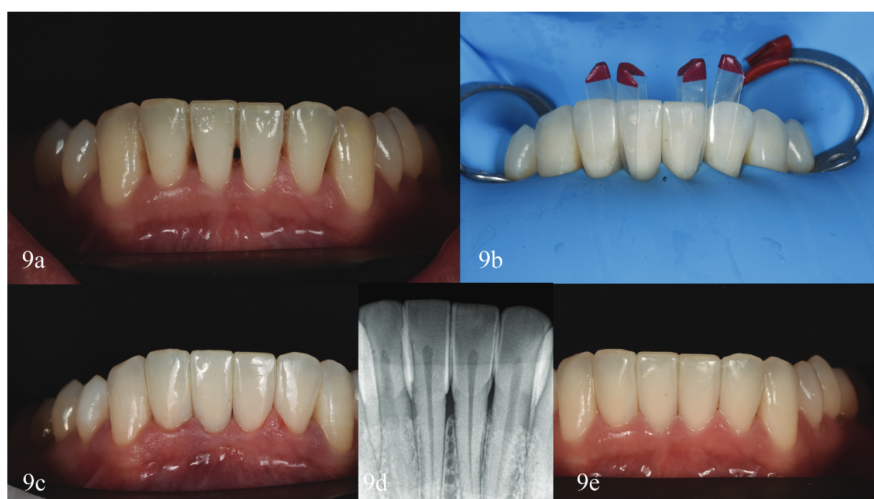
Clinical case VII. (a) Initial lower intraoral front view. (b) Detail of the isolated teeth, the small red specific matrices for black triangles installed can be seen, to do the injection molding procedure at the same time (black triangle kit. Bioclear matrix systems. Bioclear). (c) Two weeks clinical review. (d) Two weeks radiograph control, (e) Two years review, highlighting the stability of periodontal health and good polish.
